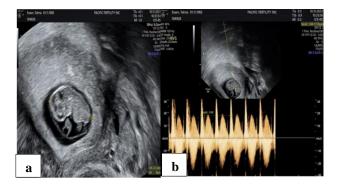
(a) and (b) Transvaginal ultrasonography of early viable pregnancy.
